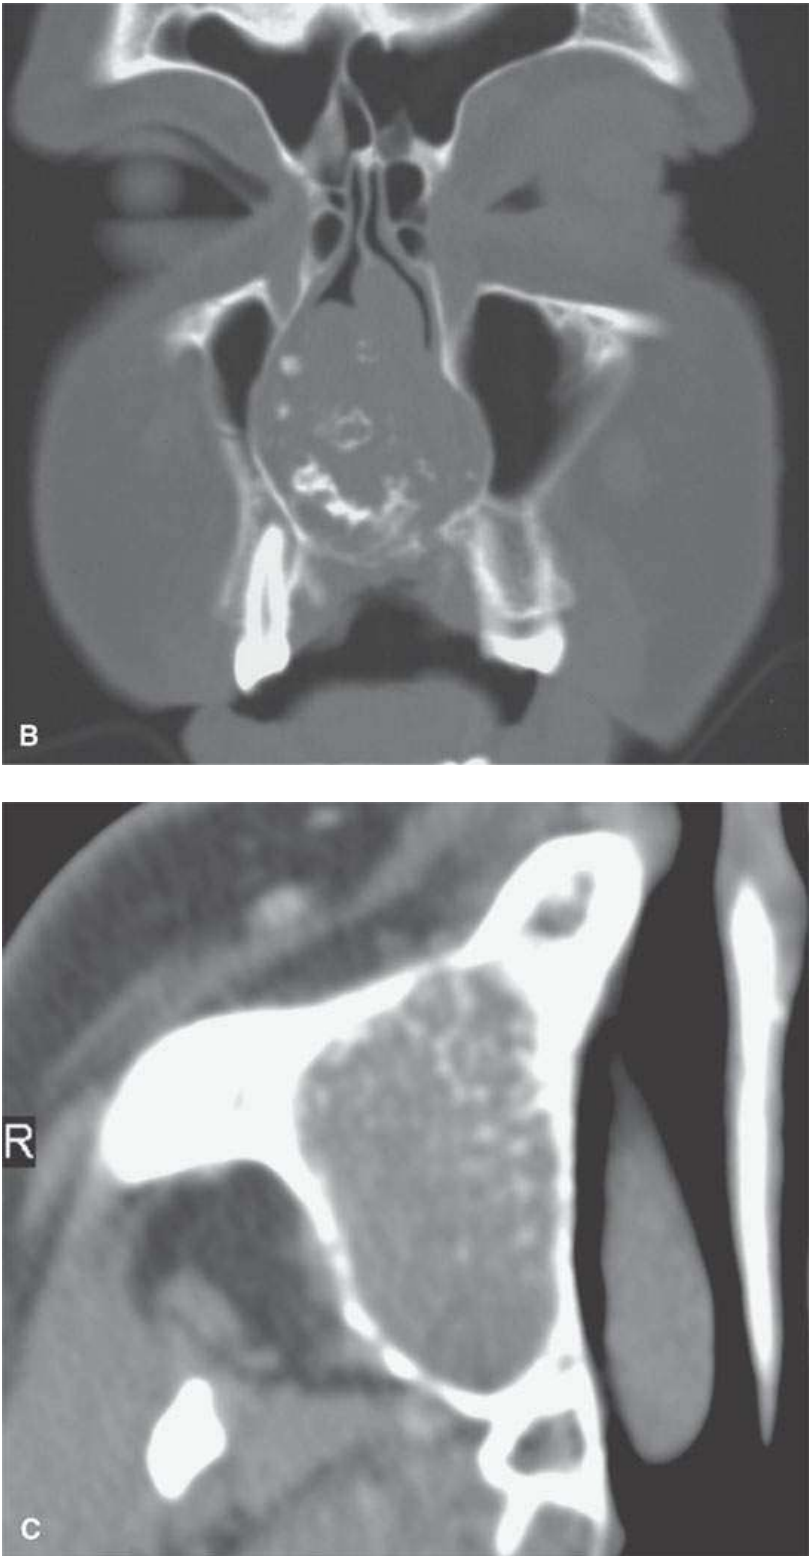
Examples where magnetic resonance would likely not make as good a diagnosis based on recognizing calcification and mineralization as computed tomography (CT) and where this information is critical to proper diagnosis. A: Contrast-enhanced CT of low-grade sialoadenitis presenting as a submandibular mass—the stone (*arrow*) and ductal dilatation is obvious on CT and might be more difficult to detect with magnetic resonance imaging (MRI) or ultrasound. B, C: CT makes the specific diagnosis of chondrosarcoma of the nasal septum (B) and chondroblastoma or at least a chondroid matrix lesion (C) that is unlikely to have been as apparent a diagnosis on MRI.
